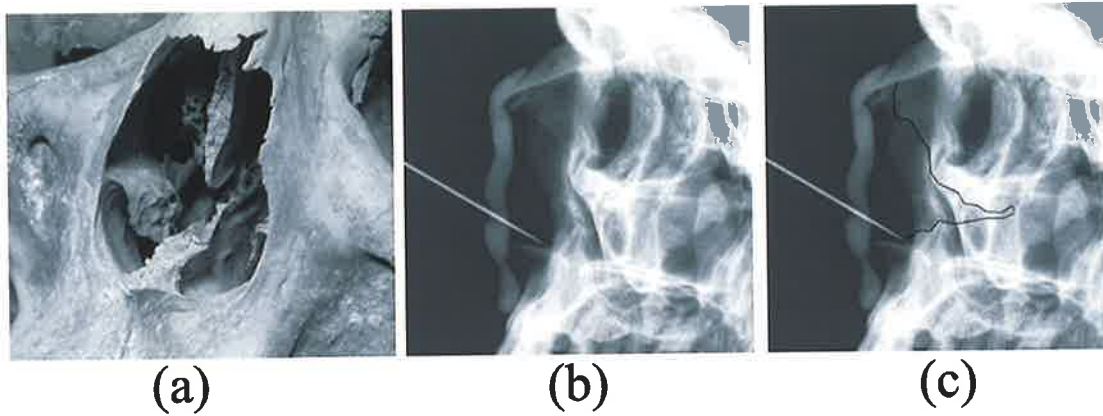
Nasal aperture and nasal septum delineation in lateral x-ray of dry skull
